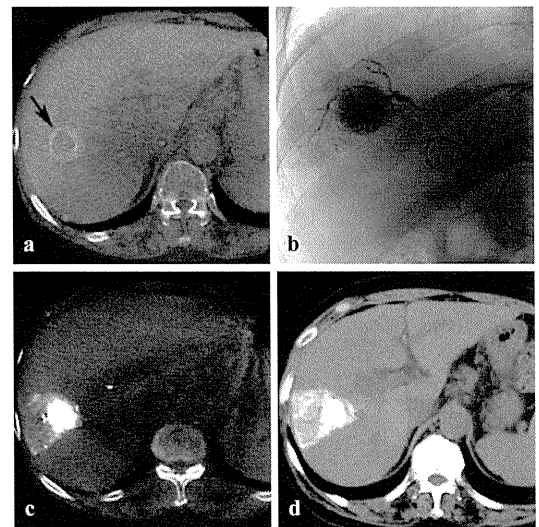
a Second-phase CBCTHA shows a tumor with thick corona enhancement in segment V (*arrow*). b One branch of the anterior inferior subsegmental artery of the right hepatic artery was embolized. c LipCBCT shows dense iodized oil accumulation in the tumor with a safety margin. d Unenhanced CT performed 1 week after TACE also shows that the tumor is completely embolized
